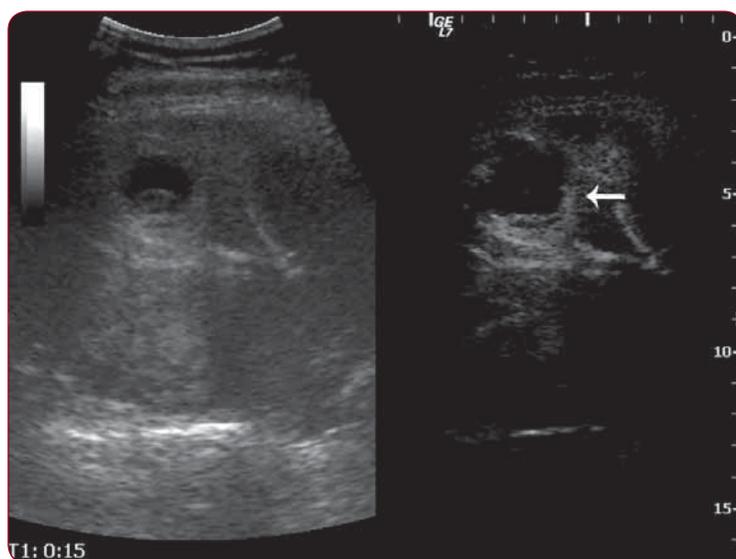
Contrast ultrasonography shows increased uptake of Sonovue in arterial phase (white arrow)
